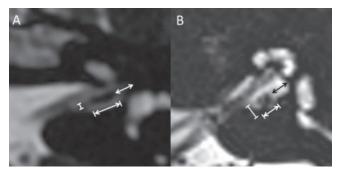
Measurements of vestibular ganglion and intracanalicular schwannoma. Axial T2-weighted images showed vestibular ganglion (A) and intracanalicular vestibular schwannoma (B). The length (\iff), width (I—I) and distance to the fundus of the internal auditory canal (\iff) of the ganglion measured 3.0 mm, 0.7 mm and 2.4 mm, respectively (A). The ratio of the length and width of the ganglion is 4.3. Similarly, the length, width and distance to the fundus of the intracanalicular schwannoma measured 2.0 mm, 1.7 mm and 2.2 mm, respectively (B). The ratio of the length and width of the schwannoma is 1.2.
